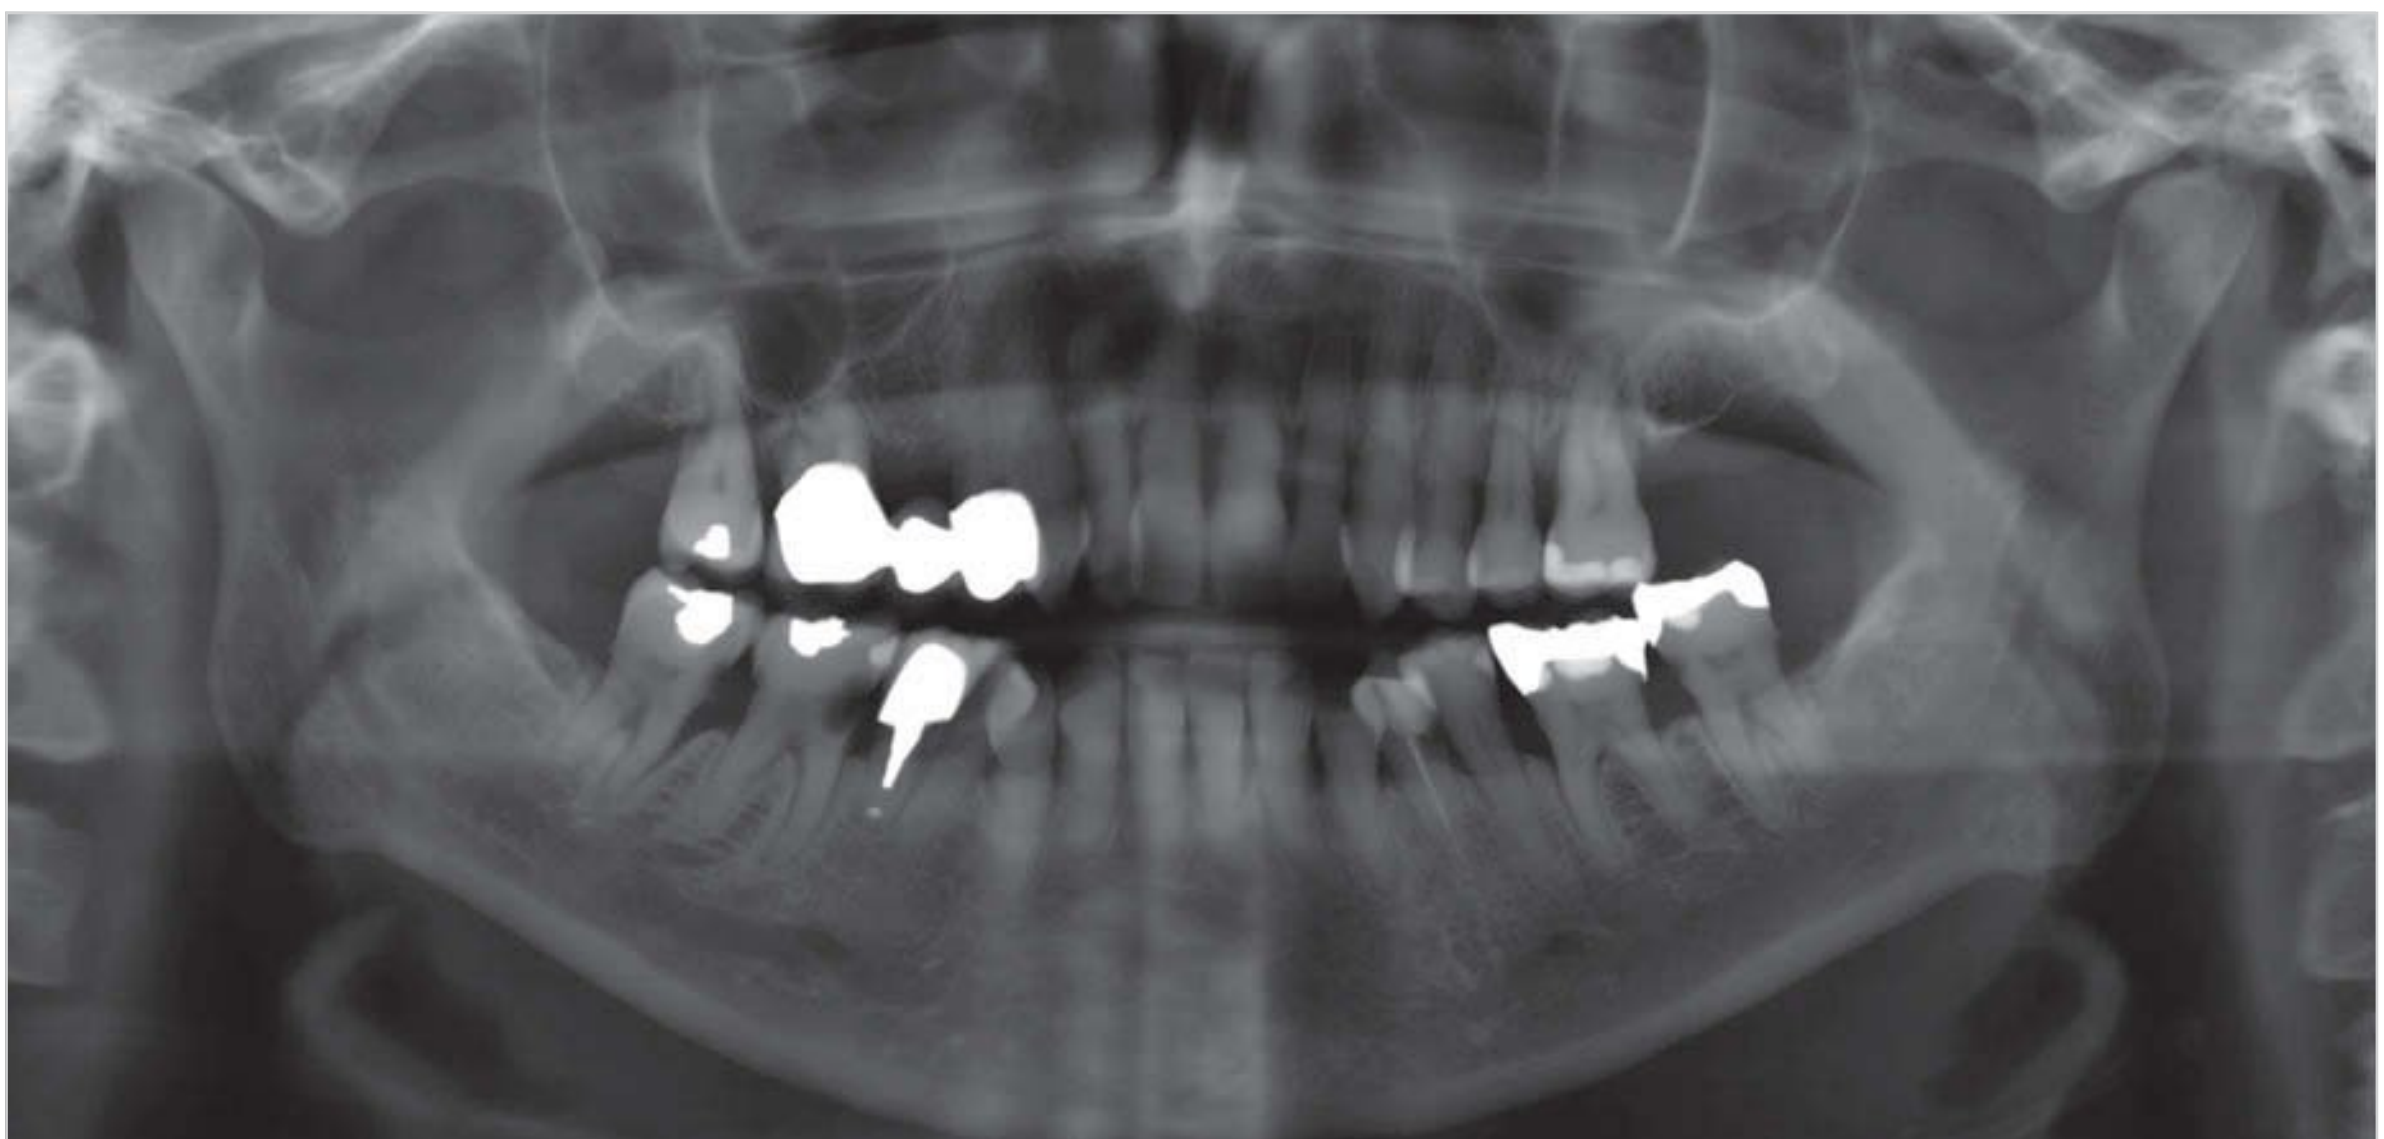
Advanced generalized horizontal bone loss and marked vertical bone defects. Periapical widening of the periodontal ligament space of tooth 26 and a large carious lesion on the mesial surface of tooth 46.
